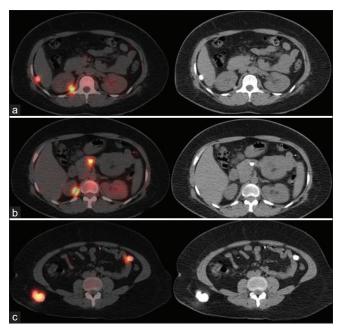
Transaxial sections of single-photon emission computed tomography/computed tomography and corresponding computed tomography images of the abdominal region (a-c) showing tracer avid diffuse calcified deposits in subhepatic and peri-renal; (a), peri-pancreatic; (b), mesenteric and right posterior abdominal wall; (c)
